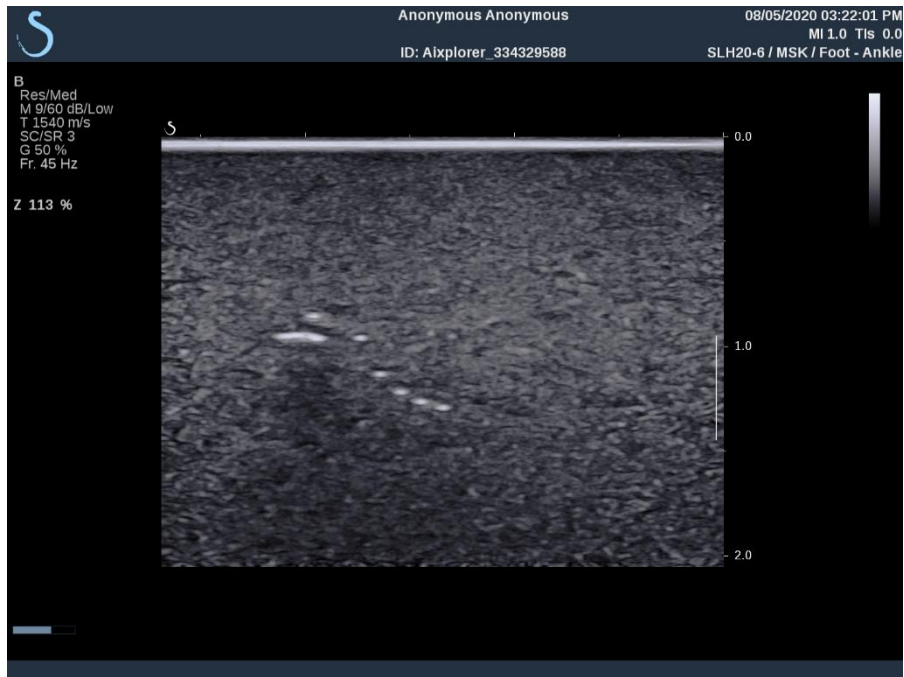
Ultrasound image used for the lateral/axial distance check. Captured with the custom SLH20-6 probe.
